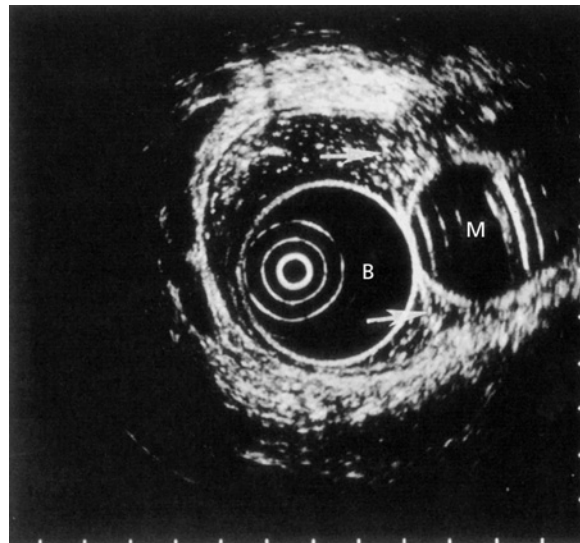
A mirror image (M) of the ultrasound transducer and water-filled balloon (B) is produced by reverberation between the transducer and the interface (arrow) between water and air within the gastric lumen.
